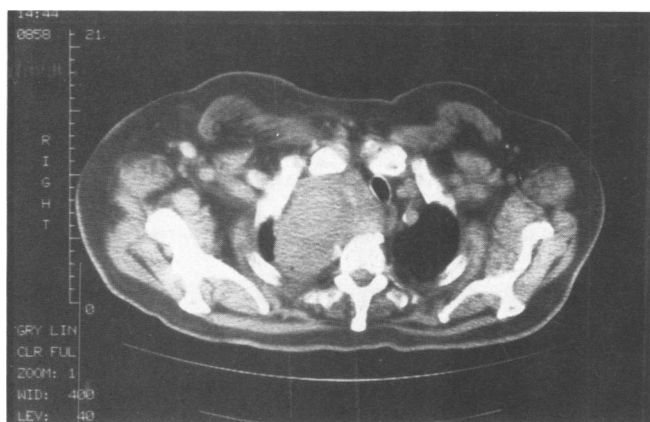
A computed tomographic scan of the upper chest shows that the mass is inhomogeneous, but no air-fluid level is present.
